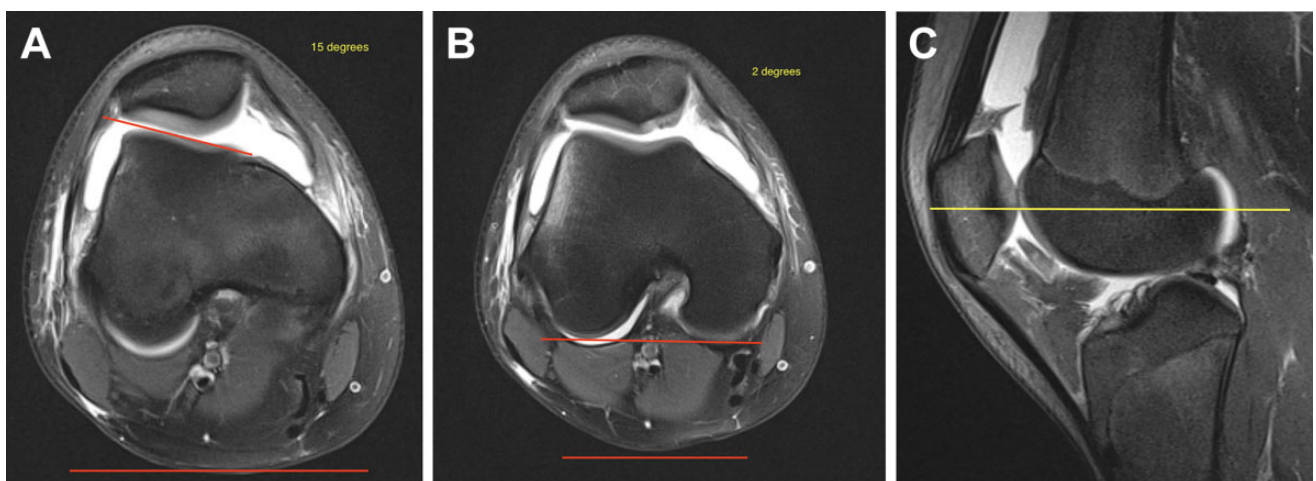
Measurement technique for 2-image lateral trochlear inclination (LTI). (A) An angular measurement was taken on an axial MRI image between the most proximal aspect of the lateral trochlear cartilaginous surface and a horizontal reference line represented by the red lines. This was the same image used for the single-image LTI. This angle measured 15° . This angle's apex was also medial, so it was assigned a positive value as well. (B) An angle was measured between the posterior condyles and a horizontal line represented by the red lines. This angle measured 2° . Because the apex of the angle was medial, it was assigned a positive value. The 2-image LTI was determined by subtracting the angle of the posterior femoral condyles relative to the horizontal from the angle of the proximal lateral trochlea relative to the horizontal. In this example, the LTI calculation was $15^\circ - 2^\circ = 13^\circ$. This was 17° different from the single-image LTI. (C) Cross-referenced sagittal magnetic resonance imaging (MRI) scan showing the level at which the measurement of the posterior condyle orientation was taken represented by the yellow line. The sagittal MRI scan showing the most proximal extent of trochlear cartilage was used. This tended to be just lateral to the intercondylar notch. In this example, the posterior condyles were measured 6 mm (2 MRI cuts) distal from the proximal trochlear measurement.
